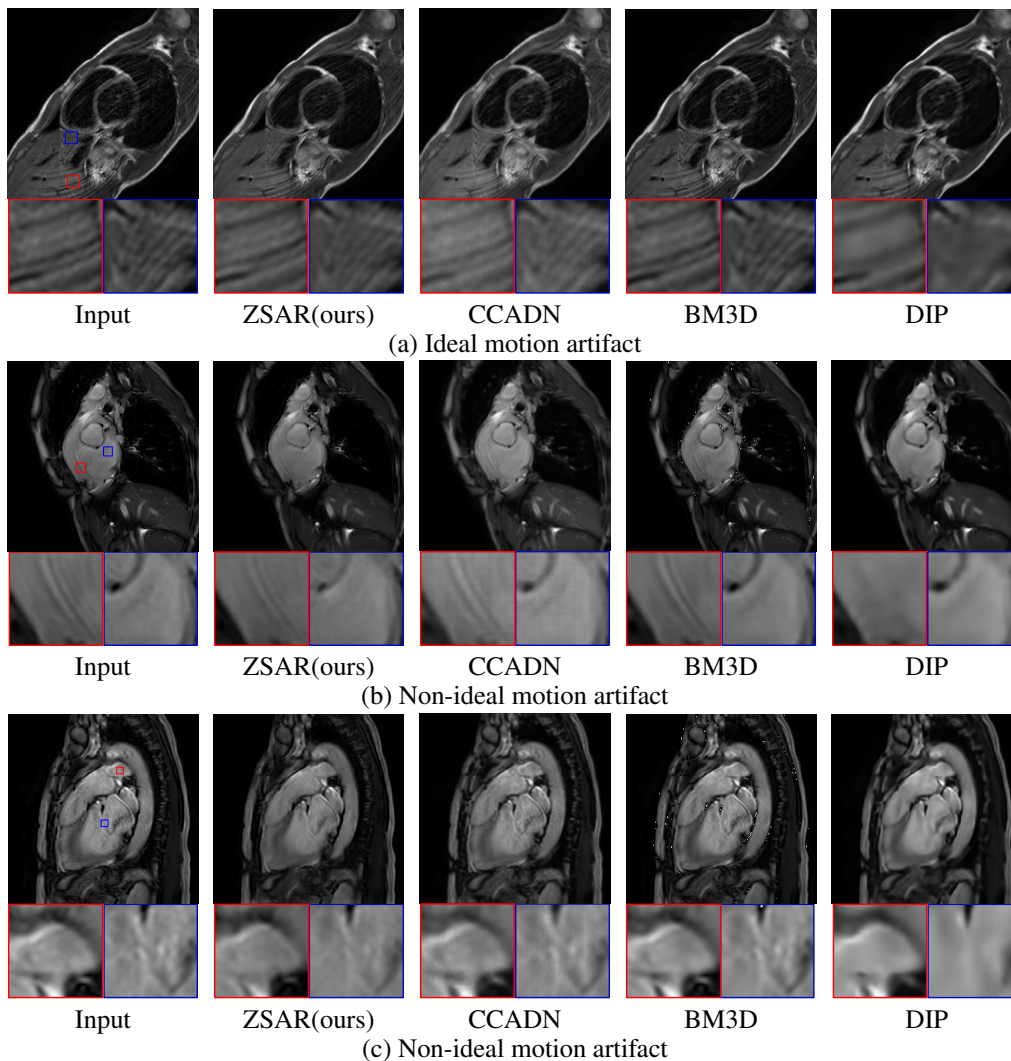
Comparison using MRI test images under (a) ideal and both (b) and (c) non-ideal scenarios. Both contain motion artifacts but the pattern in (a) appeared in the training set and but not in (b) and (c).
